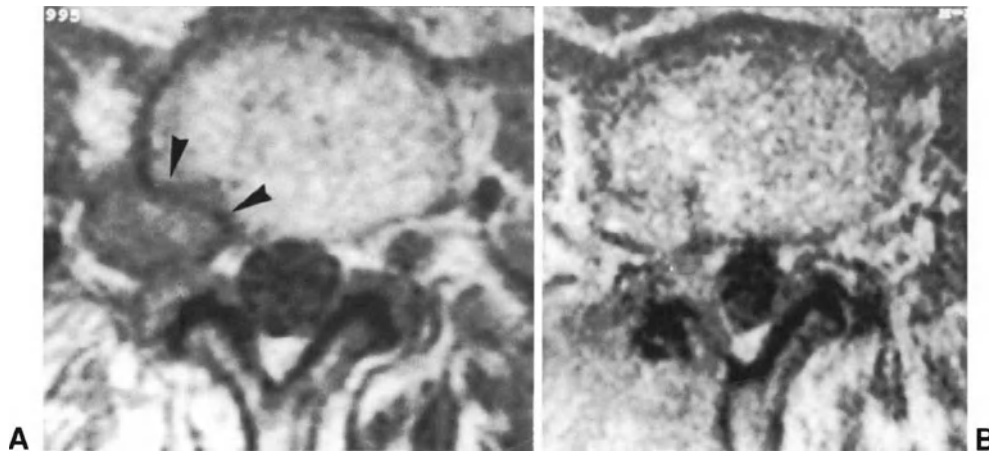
MR images of a patient with an extraforaminal disc herniation. (A) Preoperative spin-echo T1-weighted axial scan showing a large L4-L5 extraforaminal herniation on the right (arrowheads). (B) Spin-echo T1-weighted axial scan obtained 6 months after operation, performed through an interlaminar approach.
